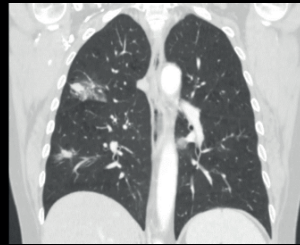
Pre-operative CT (left) and intra-operative cone beam CT (right) showing right upper lobe (RUL) nodule.
